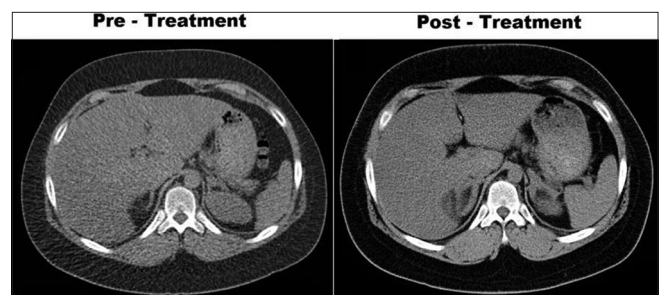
Pre- and post-treatment axial CT showing enlarging adrenal glands post treatment
